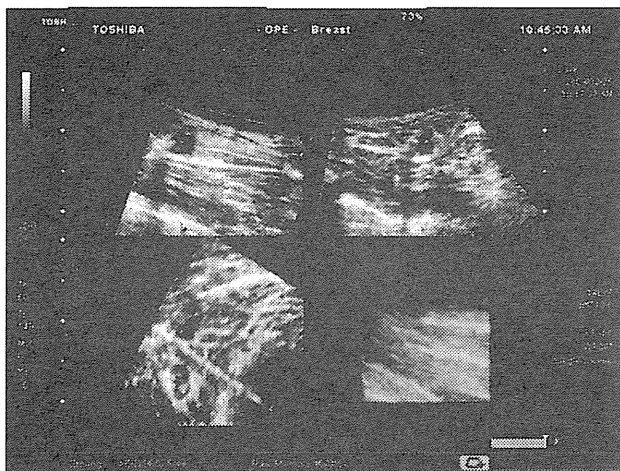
Confirmation of the location of the needle using a 4D probe. With ultrasound imaging in the two planes, we ensured that the electrode was located in the center of the lesions using a linear 2D probe for the vertical image and 4D probe for the coronary image
